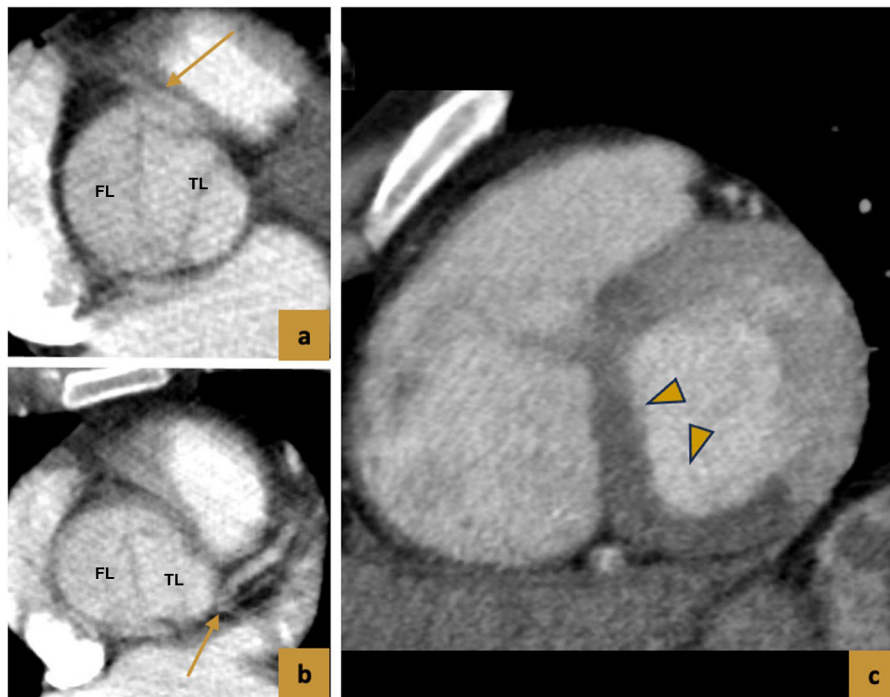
Type A dissection complicated by acute myocardial infarction. (a and b) Late arterial phase contrast-enhanced CT, axial slices showing the origin of the right coronary artery in the false lumen and the origin of the left coronary artery in the true lumen (arrows). (c) Portal phase contrast-enhanced CT, oblique slice. Transmural infarction in the inferior-septal and inferior basal segments (arrowheads) in relation to acute infarction in the right coronary artery territory.
